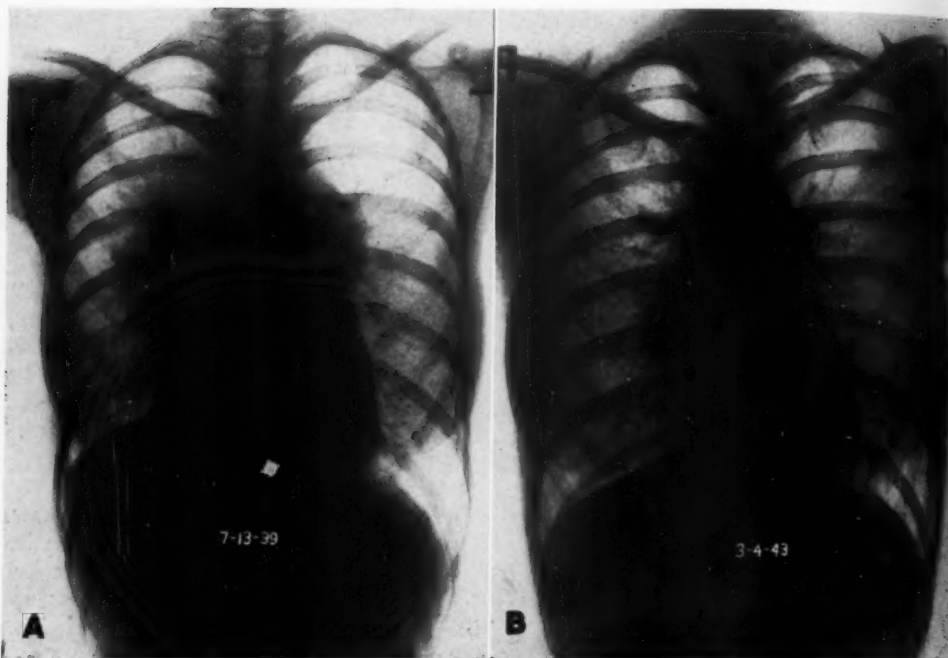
Mediastinal Hodgkin's disease. A. July 13, 1939 (biopsy of node of neck). B. March 4, 1943, following roentgen treatment (2,400 r) to tumor.
